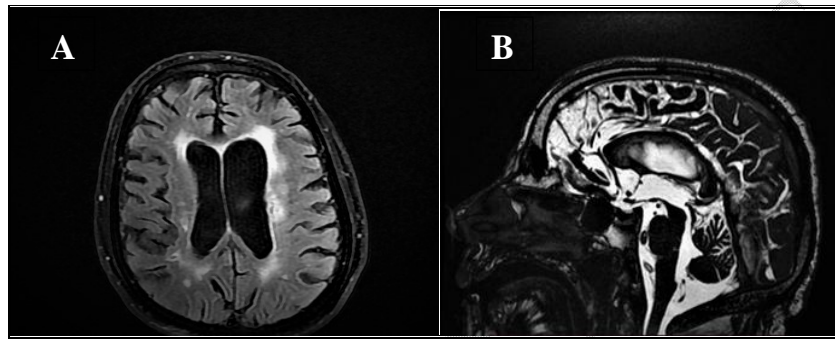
(A) Axial FLAIR and (B) Midsagittal FIESTA images show: dilated ventricular system, peripheral involutinal brain changes and leukoariosis.
